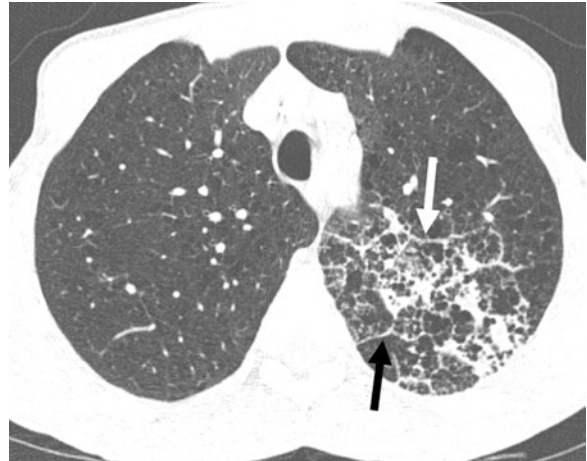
An axial chest CT in a patient with emphysema and superimposed COVID-19 pneumonia. Significant “thickening of interlobular septa” in the left lung (arrows)
